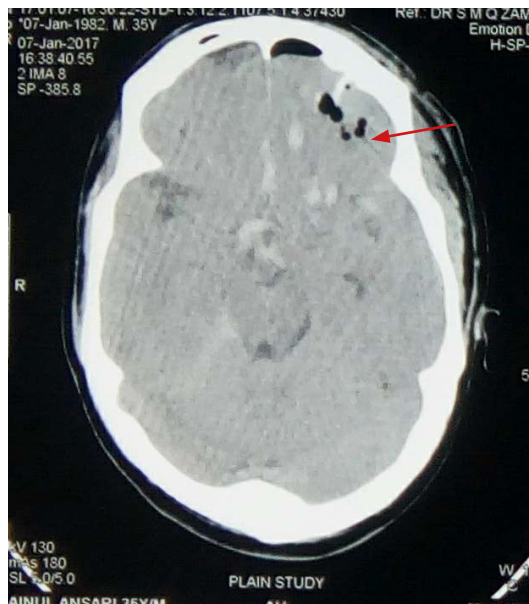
CT scan of brain showing subarachnoid haemorrhage and pneumocephalus in frontal lobe – black arrow shows subarachnoid haemorrhage, blue arrow shows pneumocephalus in frontal lobe
